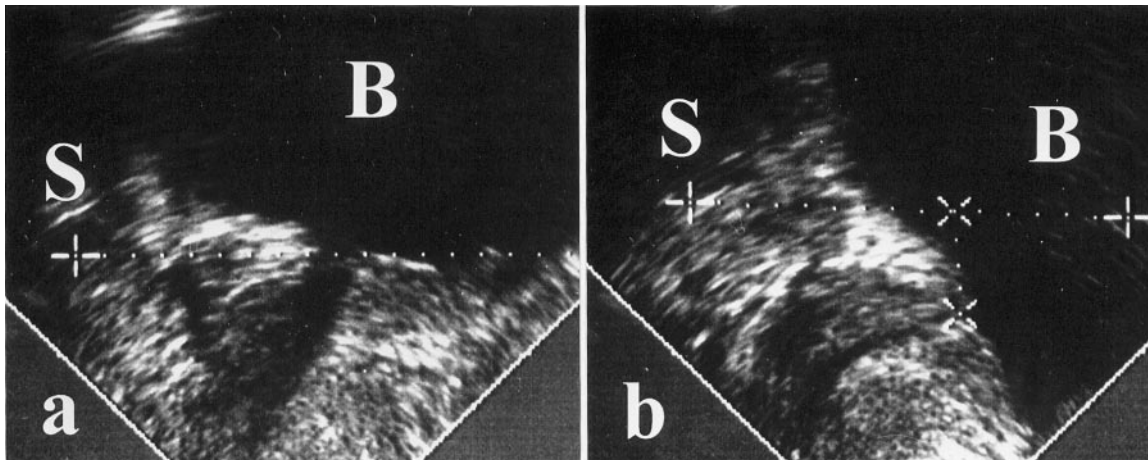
Sagittal introital ultrasound image of the pelvis showing rotational descent of both the urethra and bladder. The bladder neck is seen on the perpendicular line to the body axis at the level of the lower edge of the symphysis at rest (a), and below this line during a Valsalva maneuver (b). S, symphysis; B, bladder.
